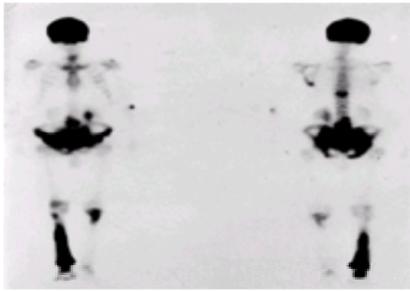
A scintigram showing a typical pagetic distribution of lesions in skull, vertebrae, pelvis, and both legs.
